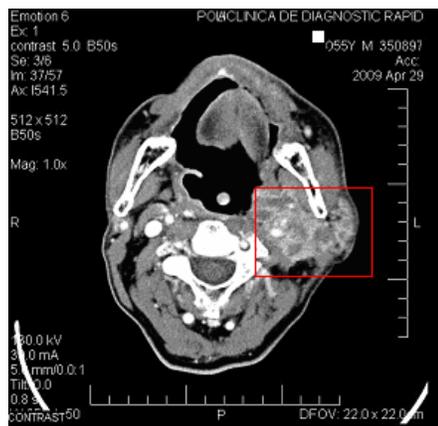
CT scan showing left sided tumour mass
